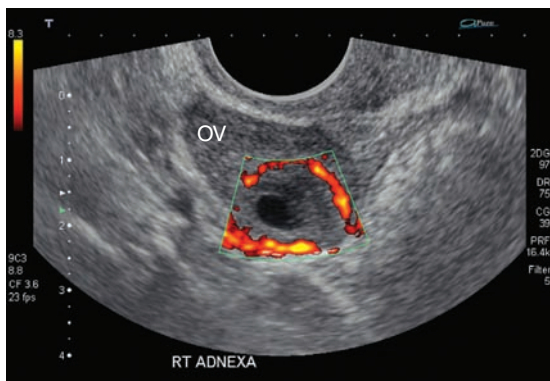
Ring of fire in ectopic pregnancy. Transvaginal view showing an ectopic pregnancy with increased vascularity on color Doppler. Ovarian tissue (OV) is seen anteriorly.
